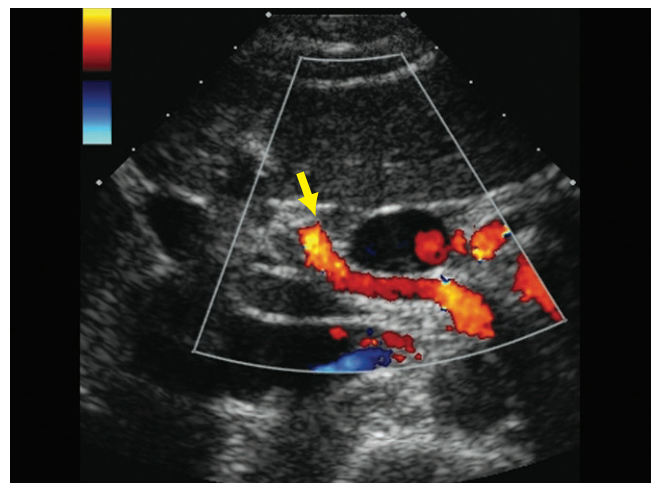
Color Doppler of the same image showing color flow in the replaced RT hepatic artery (arrow).
